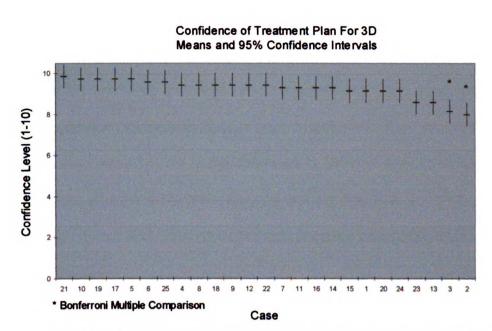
Self reported confidence of treatment plan using CBCT images. Cases are ranked from highest confidence on the left to least confident on the right. The mean was 9.2 on a scale of 1-10.
